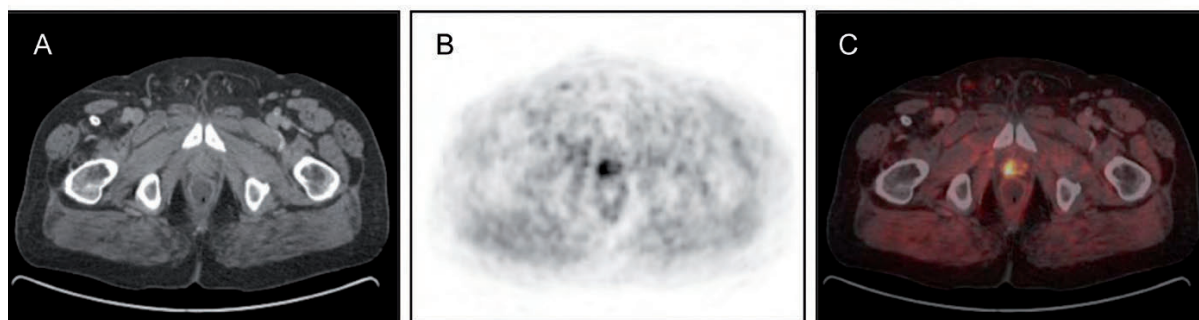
65 year old patient with prostate cancer and status after radiation therapy 11/03, referred for  $^{11}\text{C}$ -choline PET/CT due to increasing PSA up to 3,34 ng/ml.  $^{11}\text{C}$ -choline PET/CT at 11/10 revealed local recurrence (A) CT scan, (B) PET scan, (C) PET/CT fused images
